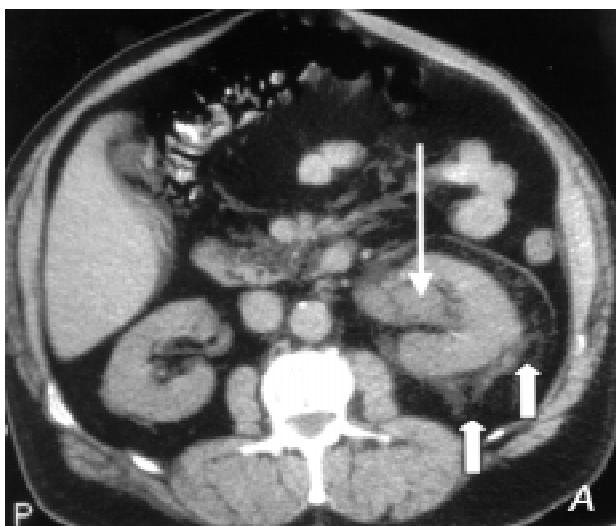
A)- Non-contrast helical CT scan reveals hydronephrosis (long arrow) and perinephric stranding (thick arrows) caused by B)- A moderate sized stone (long arrow) in the distal ureter.
